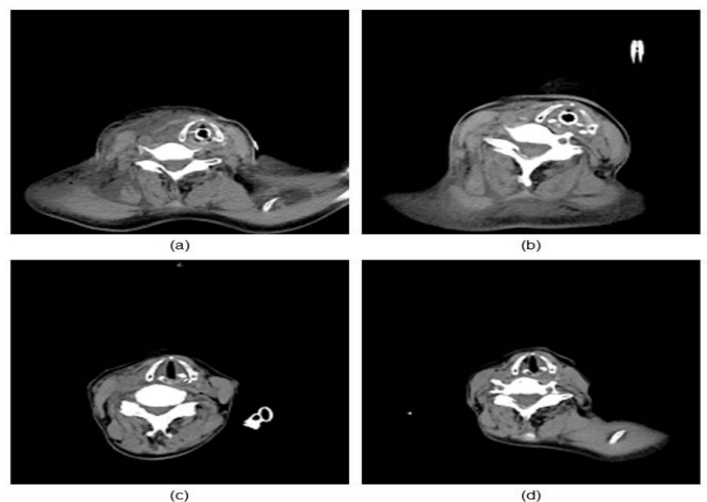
Case 2. Computed tomography images at the arytenoid cartilage level: (a) Marked deviation of the trachea due to swelling of the soft tissue and muscles on the post-operative day 1, (b) progressive soft tissue swelling on day 7, (c) soft tissue swelling and trachea deviation gradually improved on day 20, (d) swelling almost completely resolved and the trachea in the medium position on day 45.
